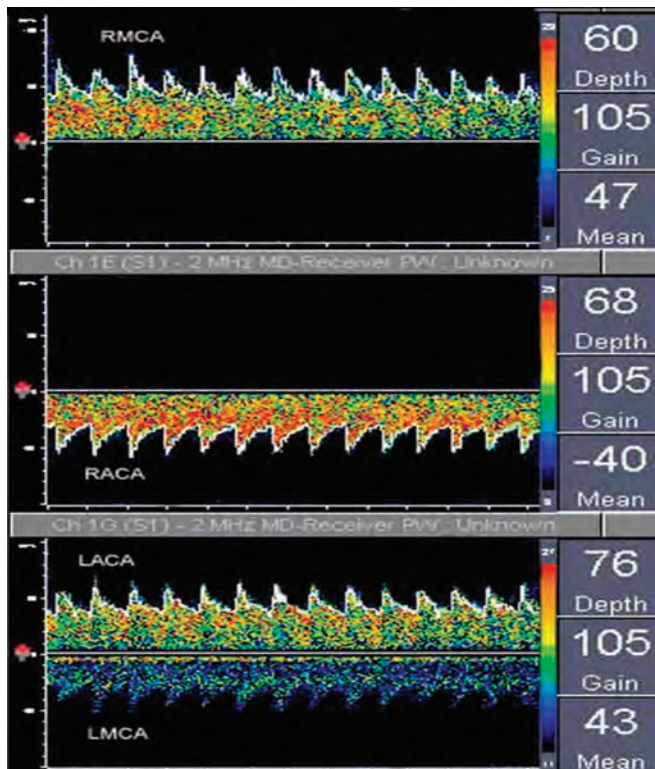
Multigated transcranial Doppler ultrasound display. Multigating of pulsed-wave Doppler signals permits simultaneous display of echo spectra generated at several different intracranial loci. LACA, Left anterior cerebral artery; LMCA, left middle cerebral artery; RACA, right anterior cerebral artery; RMCA, right middle cerebral artery.
